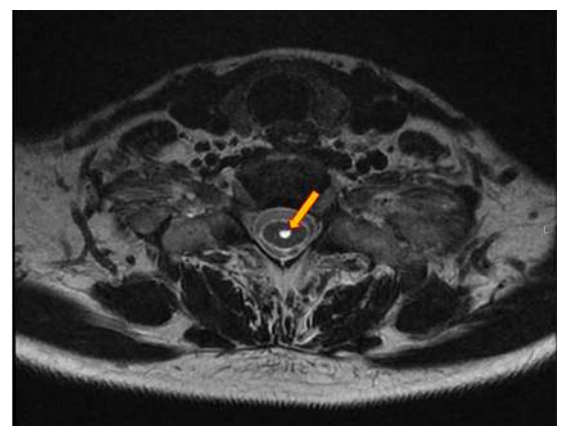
T2 weighted axial magnetic resonance image through C7-T1 showing a syrinx (arrow). Courtesy of John Carrino (Weil Cornell Medical College)
